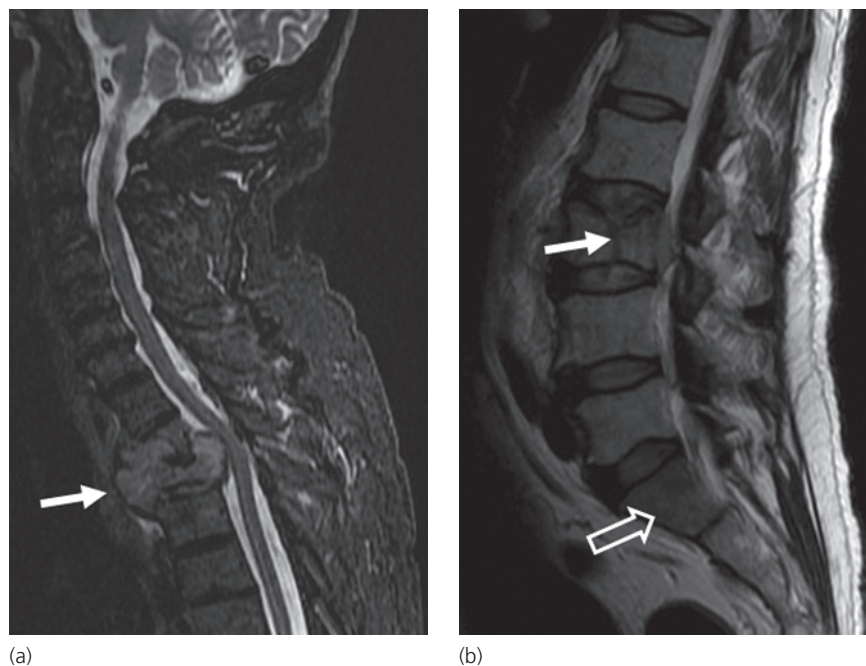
Pathologic vertebral compression fractures. (a) Sagittal inversion recovery image shows a large mass replacing the upper thoracic vertebral body (arrow) with vertebral height loss and posterior epidural mass compressing the cord. (b) Sagittal T2-weighted image in a different patient shows an L3 vertebral fracture (closed arrow) with a small epidural mass posterior to the body. An additional marrow-replacing lesion is seen in the sacrum (open arrow).
